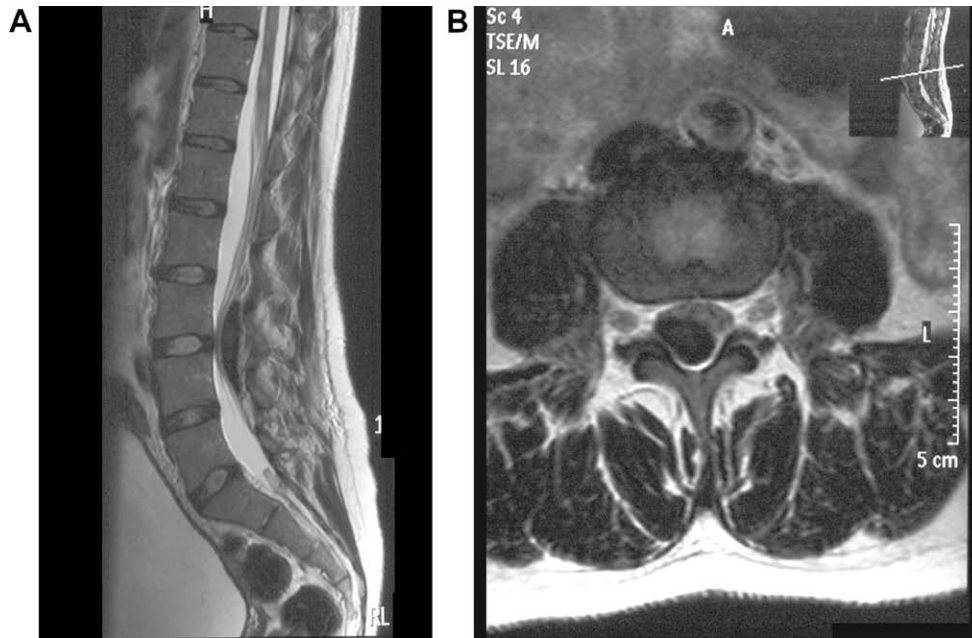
(A) Sagittal and (B) axial views from a T2-weighted MRI scan of the lumbar spine showing a hypointense lentiform mass consistent with an extradural haematoma impinging on the cauda equina.
